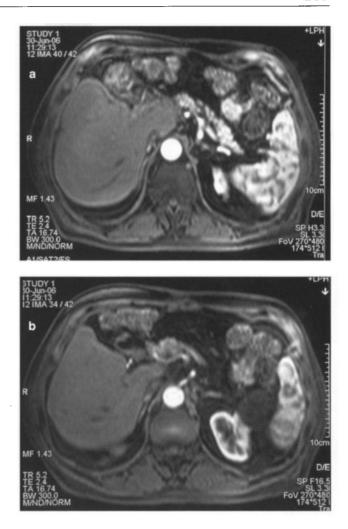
6. a-b. CT sections in the patien with cholangiocarcinoma after left hepatectomy.
